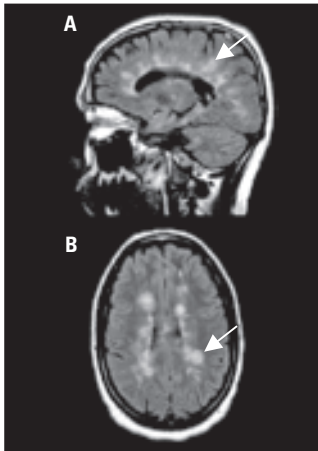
T2-weighted FLAIR
